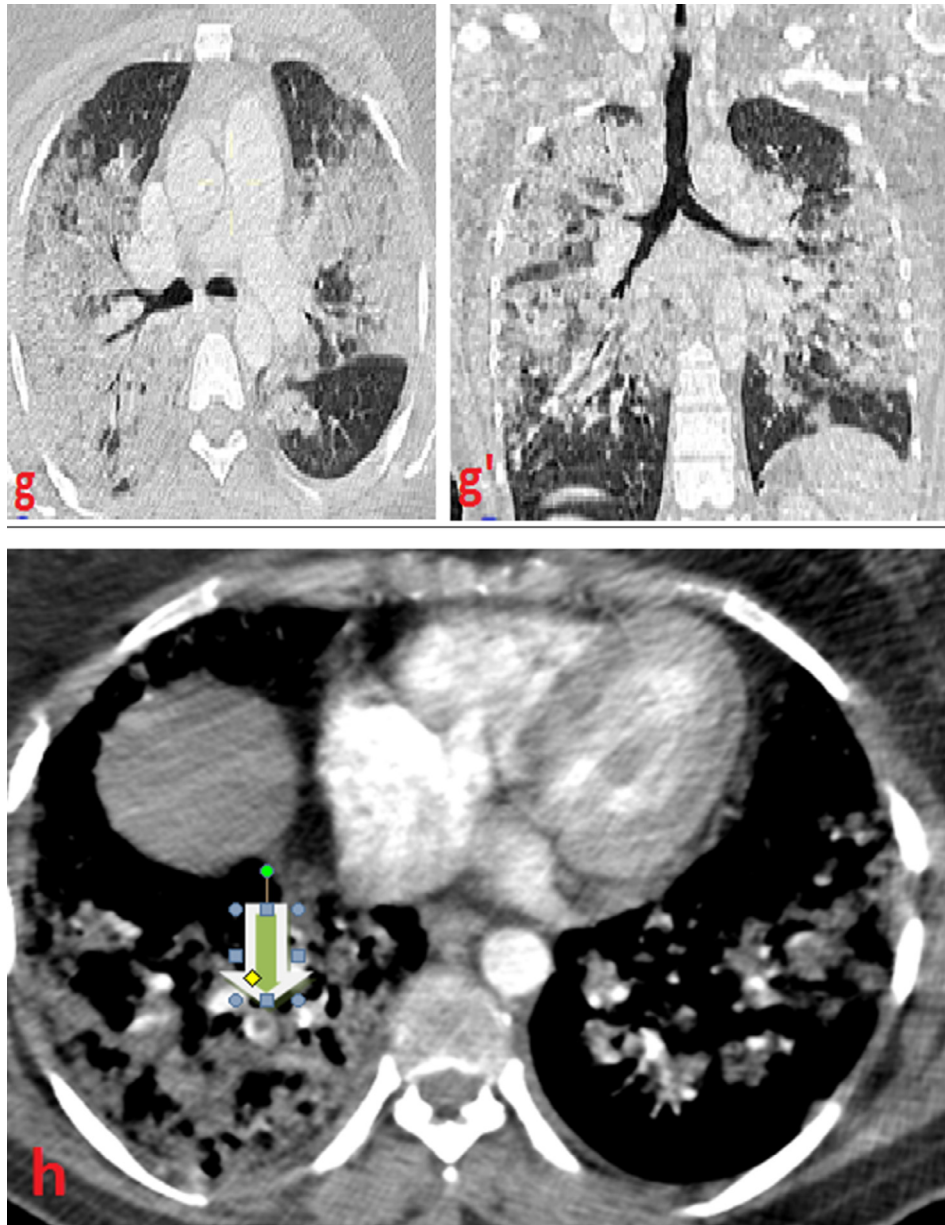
Axial (g) and coronal (g') thoracic CT: CORADS 5 lung disease, critical impairment (h), thoracic angioscan showing segmental pulmonary embolism in the lower lobar region.
